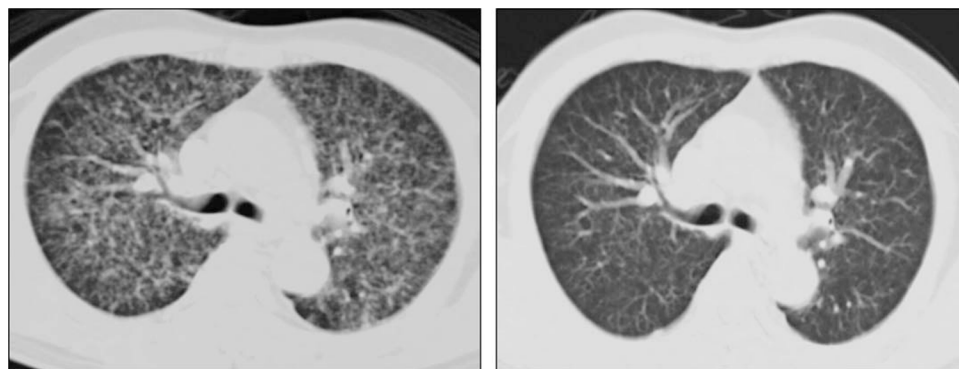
(A) CT of the thorax showing a diffuse reticulonodular pattern bilaterally which was more evident in the upper and middle zones. (B) CT of the thorax showing resolution of the reticulonodular shadowing 6 weeks after treatment.
